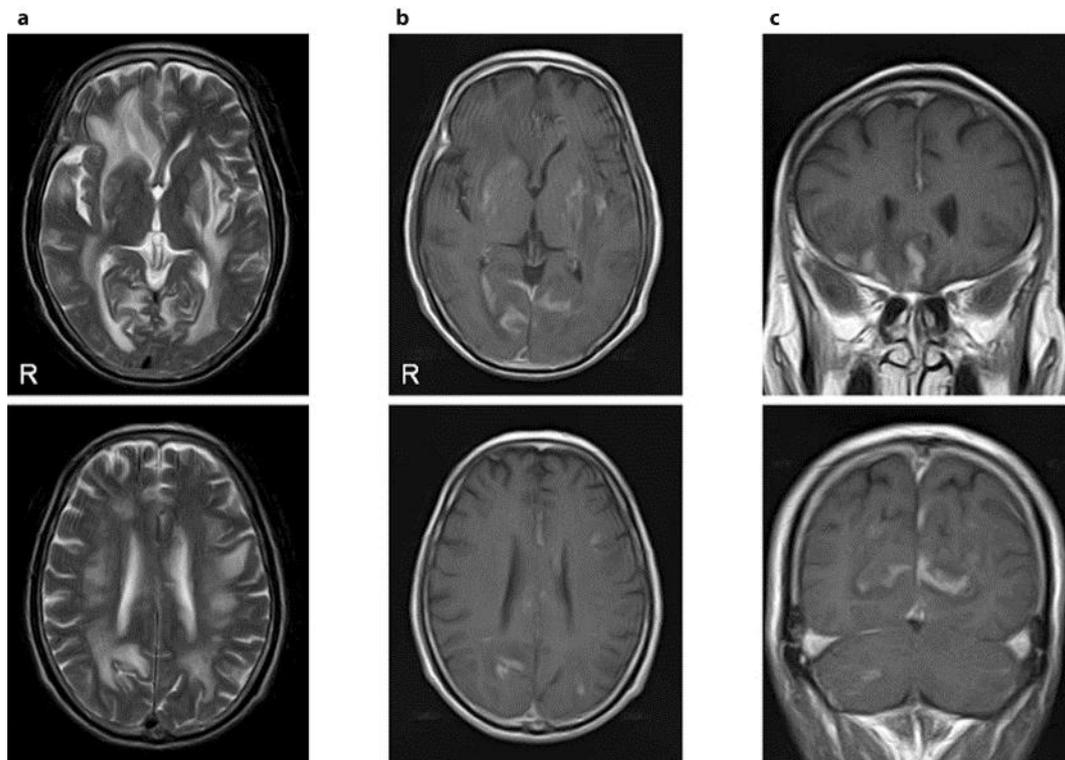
T₂-weighted axial MR images showing diffuse high intensities in the white matter (a). Contrast-enhanced T₁-weighted axial MR images showing multiple irregular enhancement in the cerebral cortex, white matter and basal ganglia (b). Contrast-enhanced T₁-weighted coronal and sagittal MR images showing gyriform enhancement in the cerebral cortex and patchy enhancement in the cerebellum (c).
